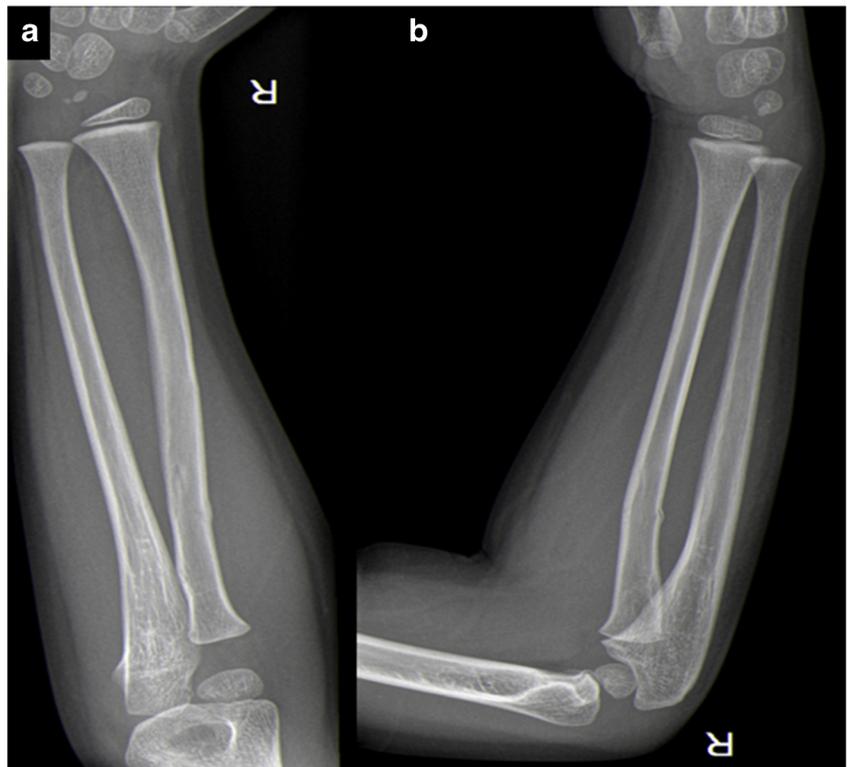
Radiographs of the right forearm 2 weeks following injury. a Postero-anterior and b lateral views demonstrate a greenstick fracture of the right ulna (*arrow*), with minimal displacement and no associated bone lesions
